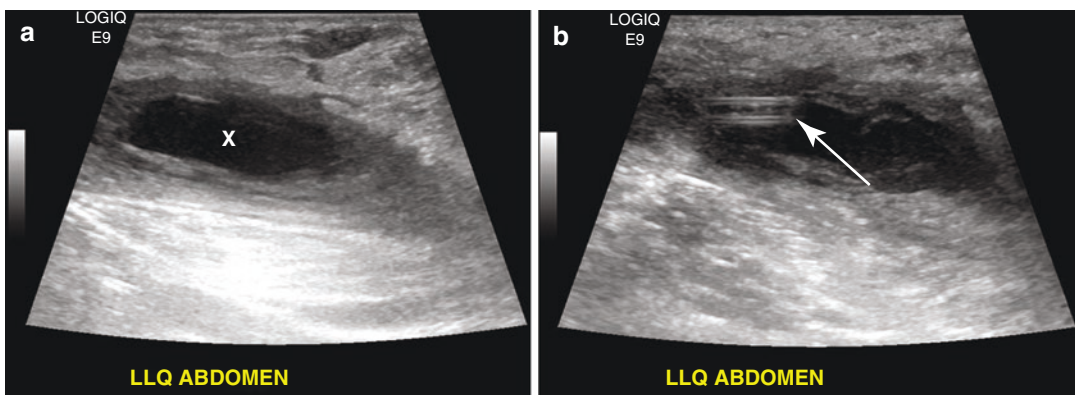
Ultrasound scan of needle aspiration of a seroma following the repair of an incisional hernia (a) Seroma collection (X) seen on ultrasound (b) Aspiration and insertion of drain (arrow) into a seroma under ultrasound guidance
